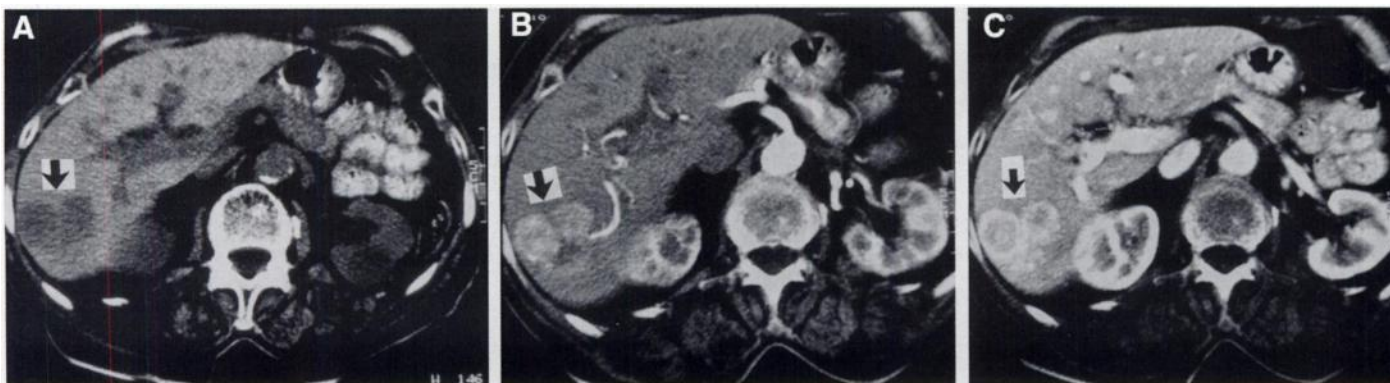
A 68-yr-old woman with hepatic carcinoid metastasis. CT scan of the liver shows a hypervascular lesion. The pattern of peripheral enhancement was suggestive for a hemangioma rather than a metastasis. (A) Native CT. (B) Contrast-enhanced CT, arterial phase. (C) Contrast-enhanced CT, portal venous phase.
